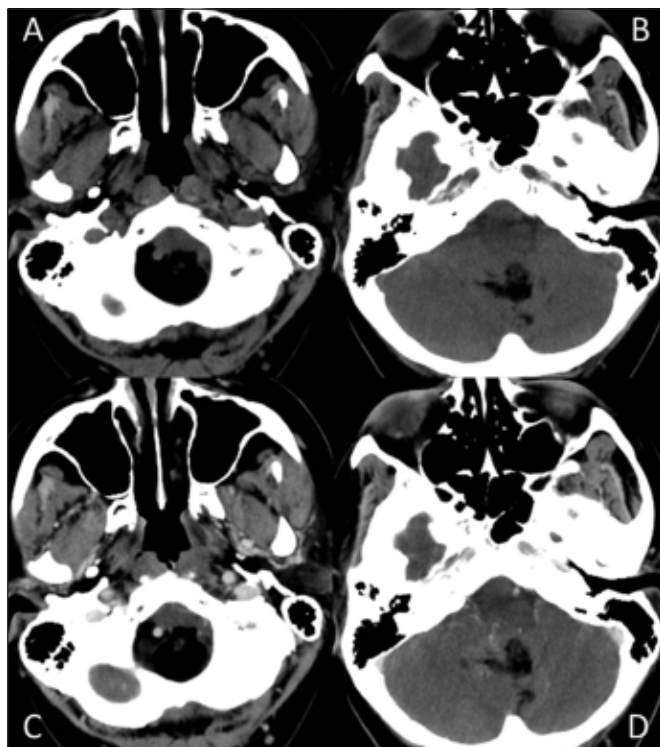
(A,B) Axial CT images of the brain demonstrating a mixed fatty / solid midline posterior fossa mass. (C,D) Following iodinated intravenous contrast, the solid portions of the mass enhance.
